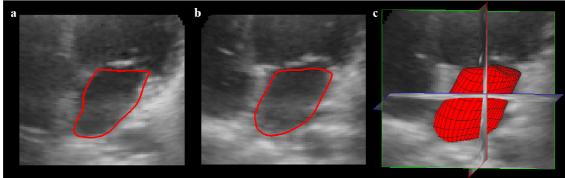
LA segmentation example in a 3D echocardiography image using a semi-automated algorithm [150]. a and b: long axis views; c: triplane-view and 3D rendering.
